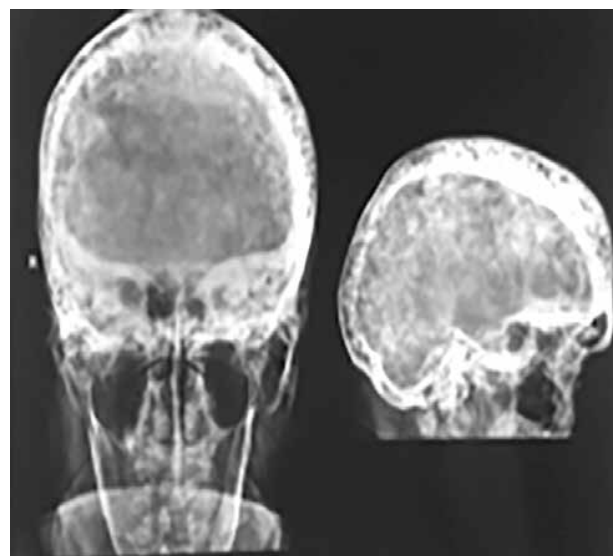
X-ray skull showing cotton wool appearance.
